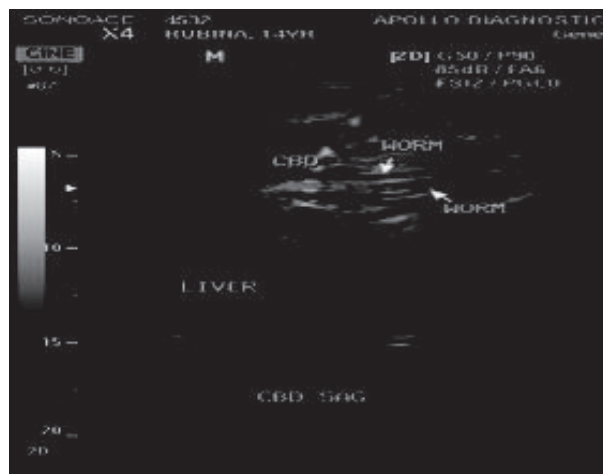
Tubular echogenic structure with a central anechoic tube (Inner tube sign) within the common bile duct at ultrasonography
